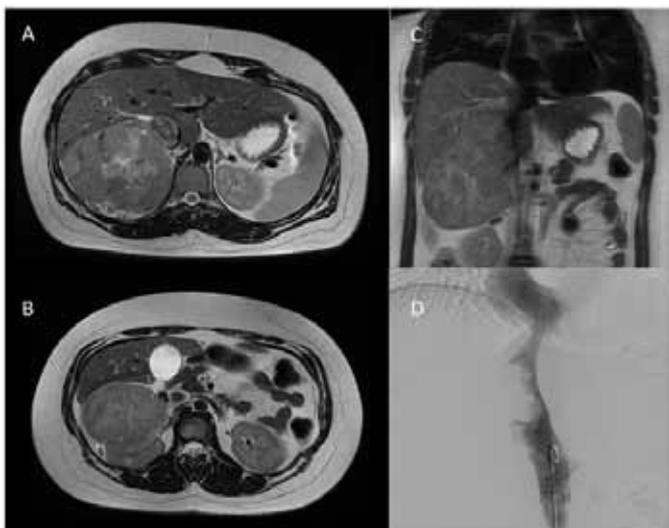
Magnetic resonance imaging demonstrating (A) Right adrenal mass involving the IVC with tumor thrombus, (B) Origin arising from the right adrenal, (C) A coronal view showing IVC extension to the level of the hepatic veins; and (D) A venogram demonstrating IVC thrombus with resulting stenosis.
